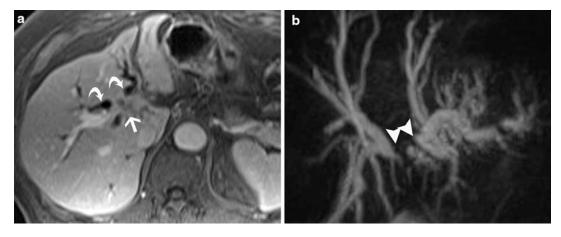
A 73-year-old man presenting with obstructive jaundice. Axial, fat-suppressed, enhanced T1-weighted MR image (a) shows slightly enhancing mass (*arrow*) involving the biliary bifurcation and dilated intrahepatic
